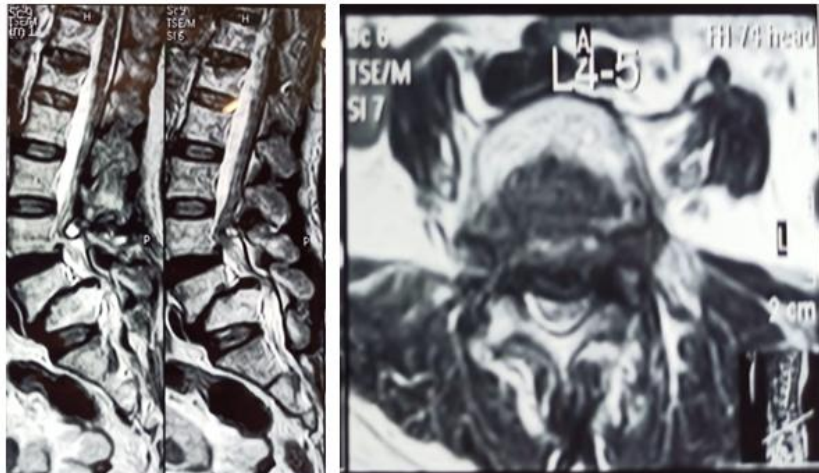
MRI LS spine T2 weighted sagittal and axial images
